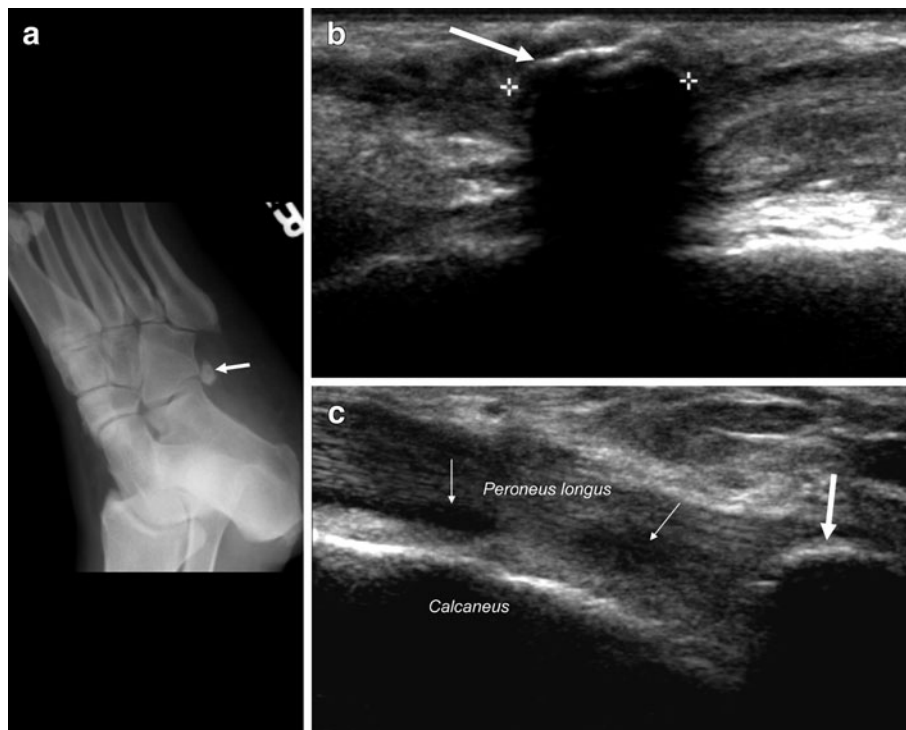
This 54-year-old woman presented with chronic lateral ankle pain. An oblique supine radiograph (a) of the foot demonstrates a 12-mm os peroneum at the calcaneocuboid joint (arrow). Short-axis sonographic image demonstrates the characteristic ultrasound appearance of the os peroneum, with a curvilinear hyperechoic superficial margin (arrow) with posterior acoustic shadowing (b). Caliper
